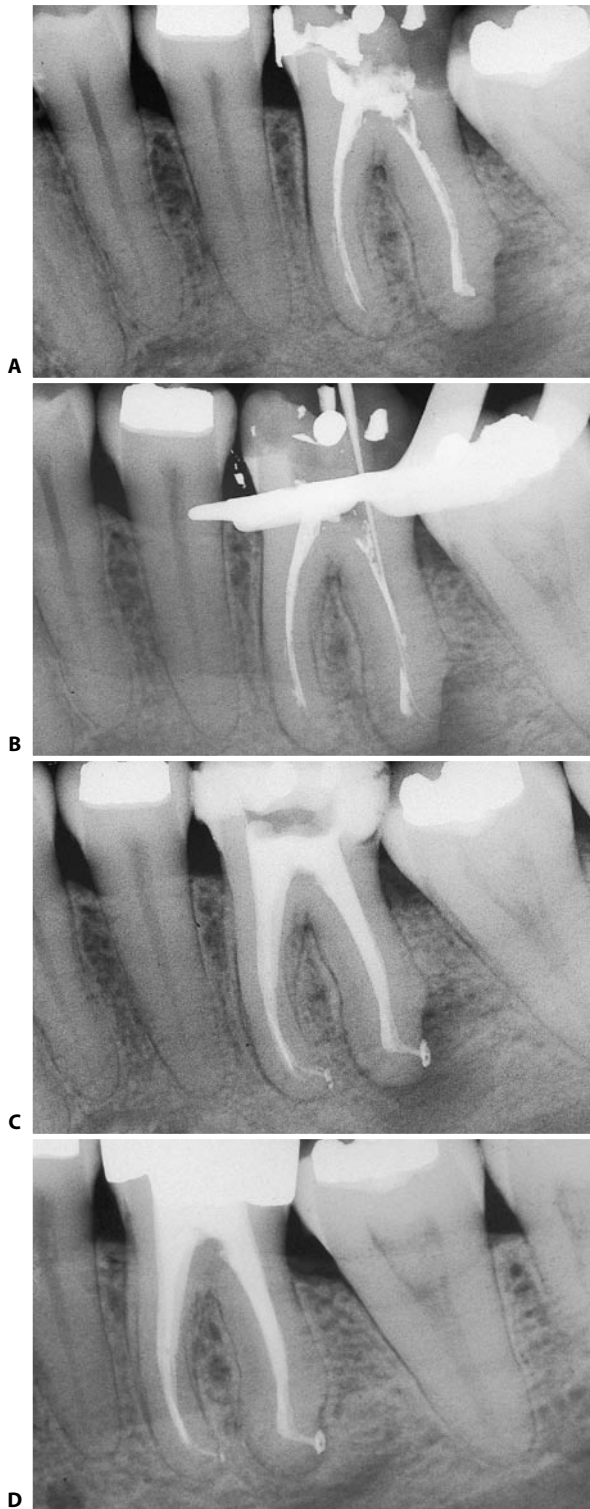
The distal root canal of the lower molars often faces distally, sometimes with an angle of about 90° . If the instruments are not precurved, the obturation will be short, possibly leaving one with the impression that one has reached the cementodentinal junction or the apical constriction. A. Preoperative radiograph. The canals were treated with iodoformic paste. B. An adequately precurved # 08 file follows the pronounced curvature of the canal. C. Postoperative radiograph. D. Recall radiograph two years later. Note that the obturation has been made at the radiographic terminus of the canal and, at the same time, is at least three millimeters short from the radiographic apex!
